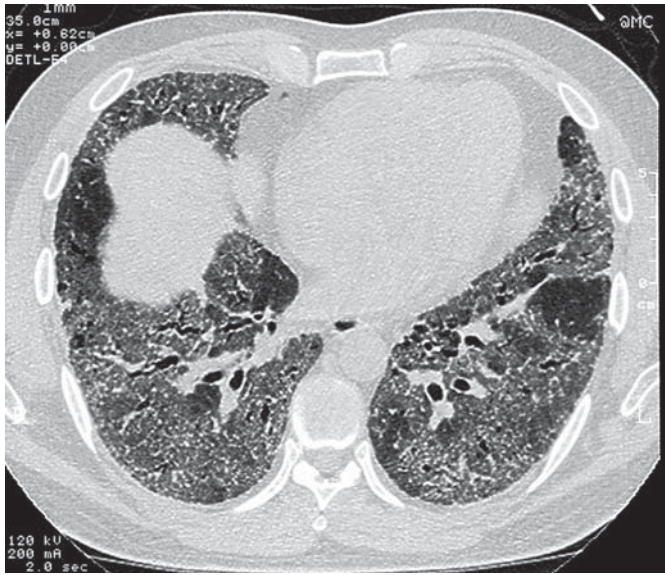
HPS. HRCT scan at the lung basis. Interlobular and intra-lobular reticular lines with architectural derangement.
